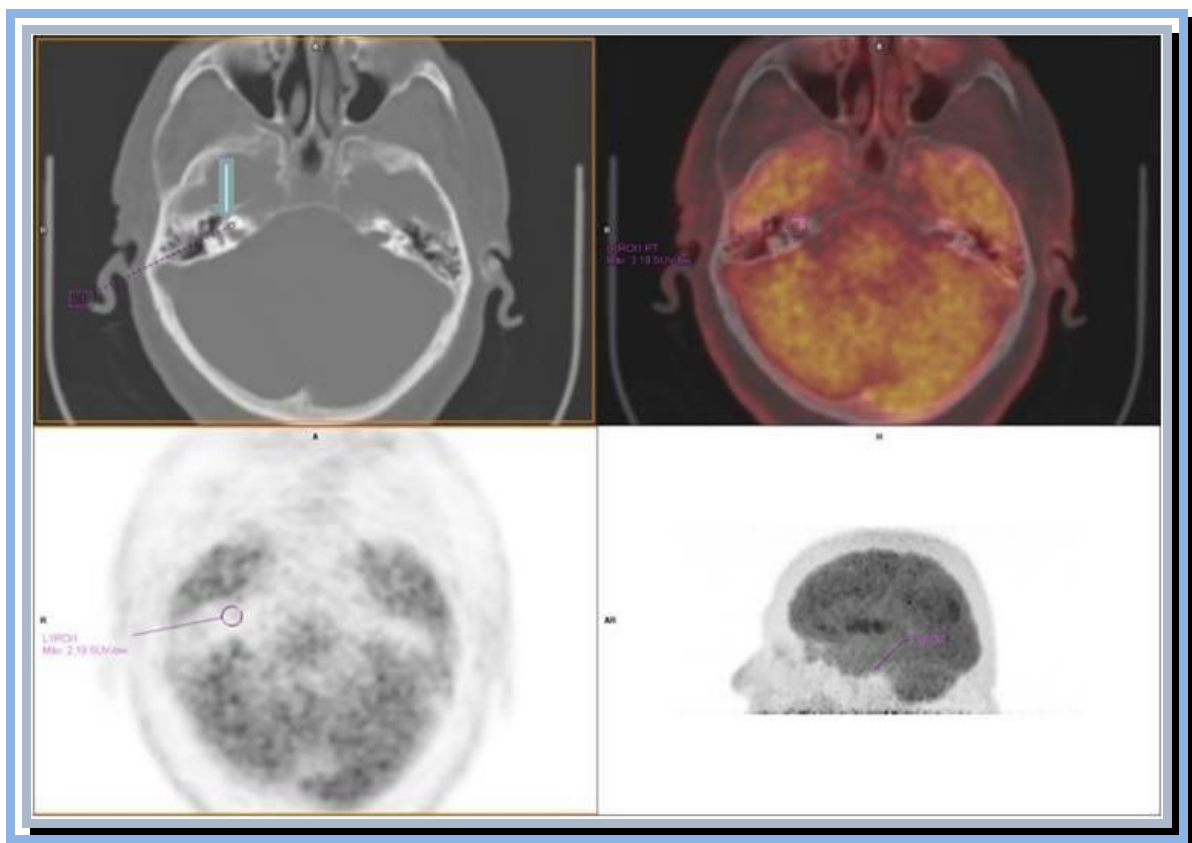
Captación de 18-FDG observada en el oído interno con un SUV de 2.19.
